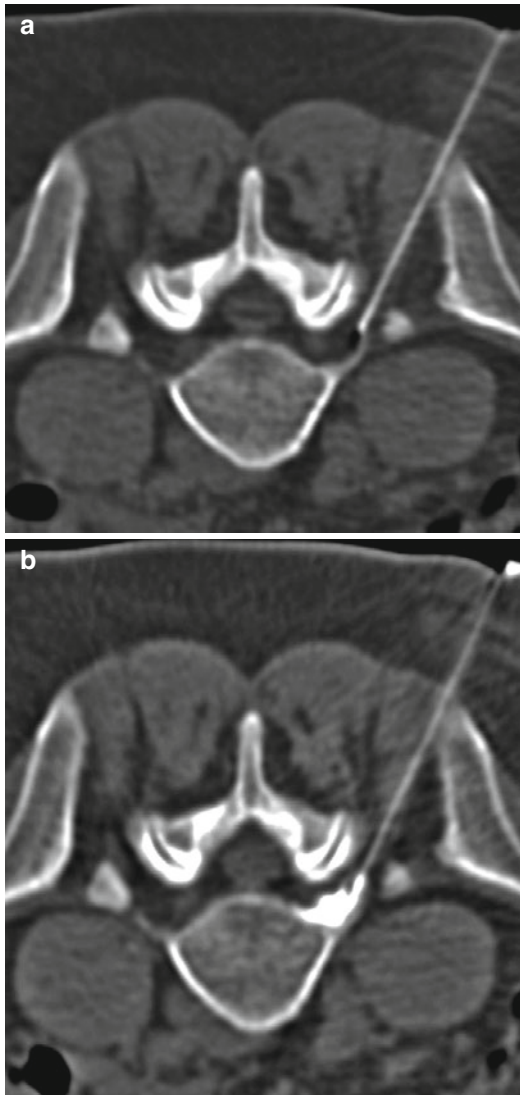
CT-guided periradicular therapy of the lumbar spine. After CT-guided paraspinal needle placement (a), a steroid mixed with contrast medium was injected (b)
